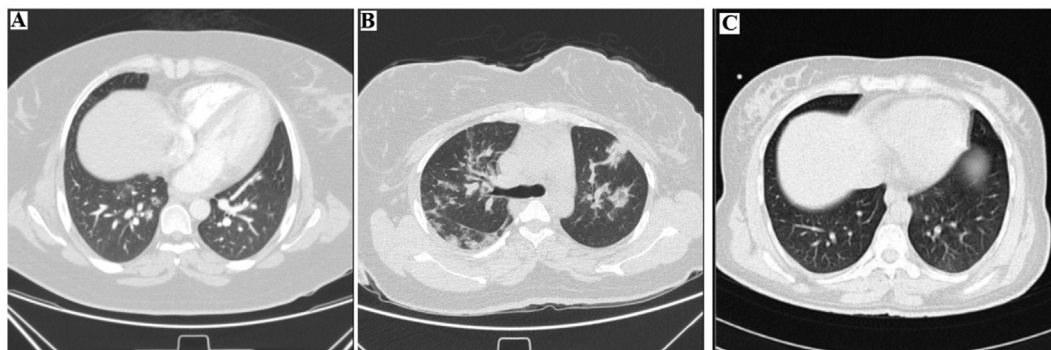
Chest high-resolution computed tomography (CT). (A) Pulmonary CT angiography to exclude pulmonary thromboembolism. (B) Peripherally predominant airspace consolidations, linear and ground-glass opacities in both side lung fields. (C) Normal lung high-resolution CT.
